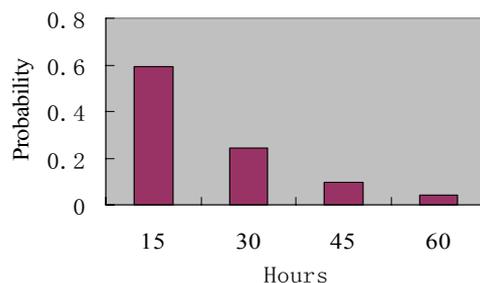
A negative exponential distribution of B-ultrasound service time
